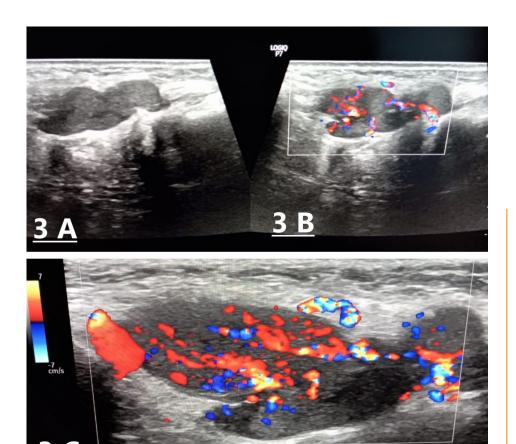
A) Greyscale ultrasound image showing lobulated tubular structure containing heterogeneous hypoechoic thrombus grossly distending the right facial vein with resultant occlusion; B) The colour Doppler image shows intense vascularity within the thrombus as shown by coloured areas; C) The focused colour Doppler ultrasound image through the right facial vein demonstrates vivid intrathrombus vascularity. No free flow is otherwise present in the background right facial vein (not shown in the figure).
